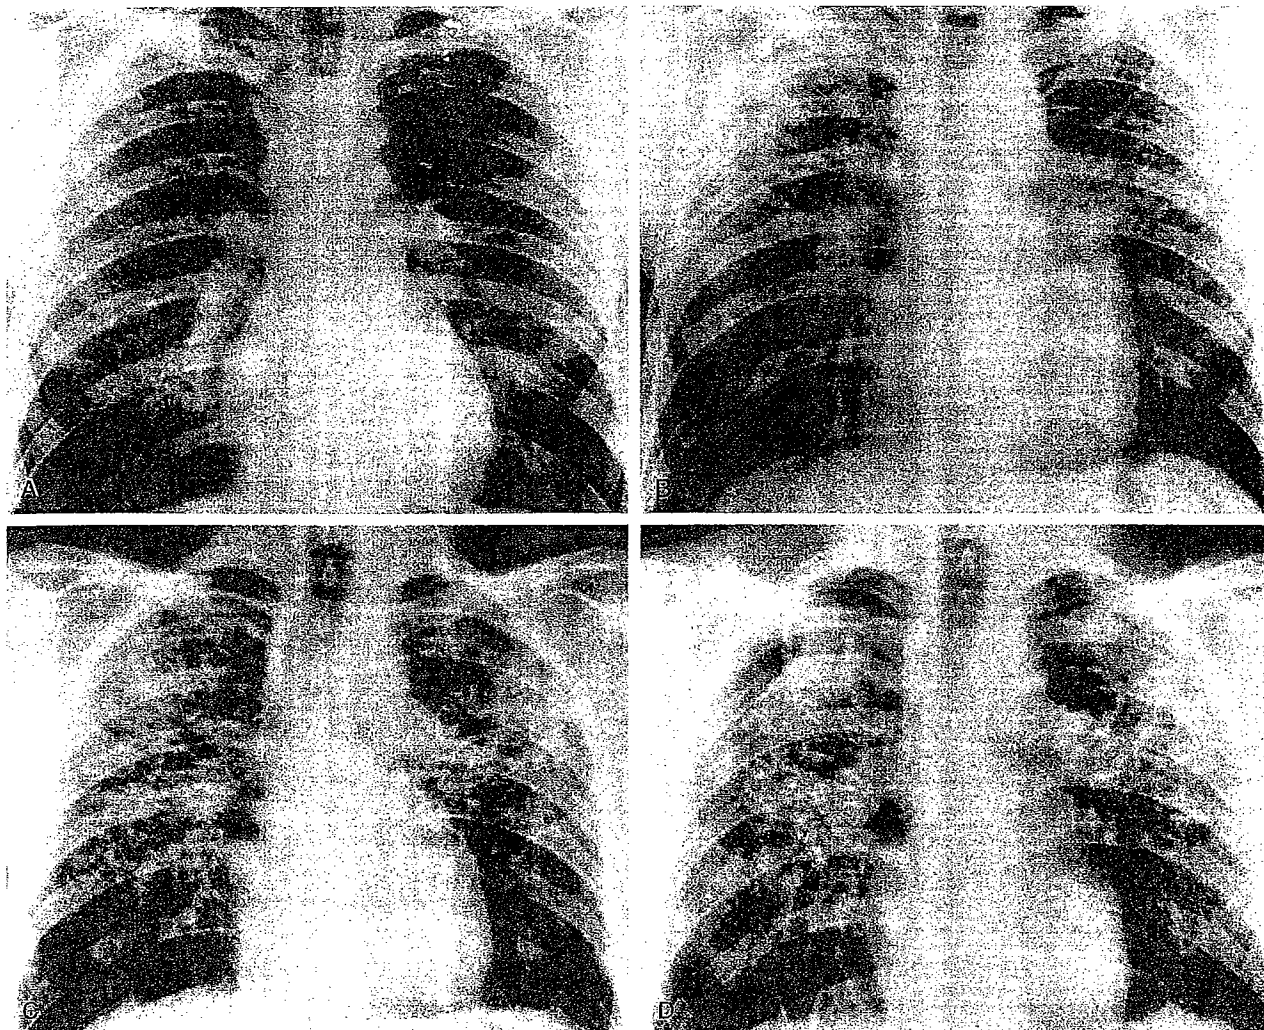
Silicosis Showing Rapid Progression. A radiograph of a 27-year-old sandblaster (A) reveals diffuse, predominantly irregular opacities more prominent in the upper lung zones; hilar lymph nodes are enlarged. Two years later (B), lung volume had reduced somewhat, particularly in the upper lung zones (note the upward displacement of both hila). The opacities in the upper lungs were showing early coalescence. Three years later (C), large opacities had developed in the upper lung zones, and 7 years after he was originally seen (D), the large opacities had become much larger. Note the sharply defined lateral margin of the large opacity on the right.
